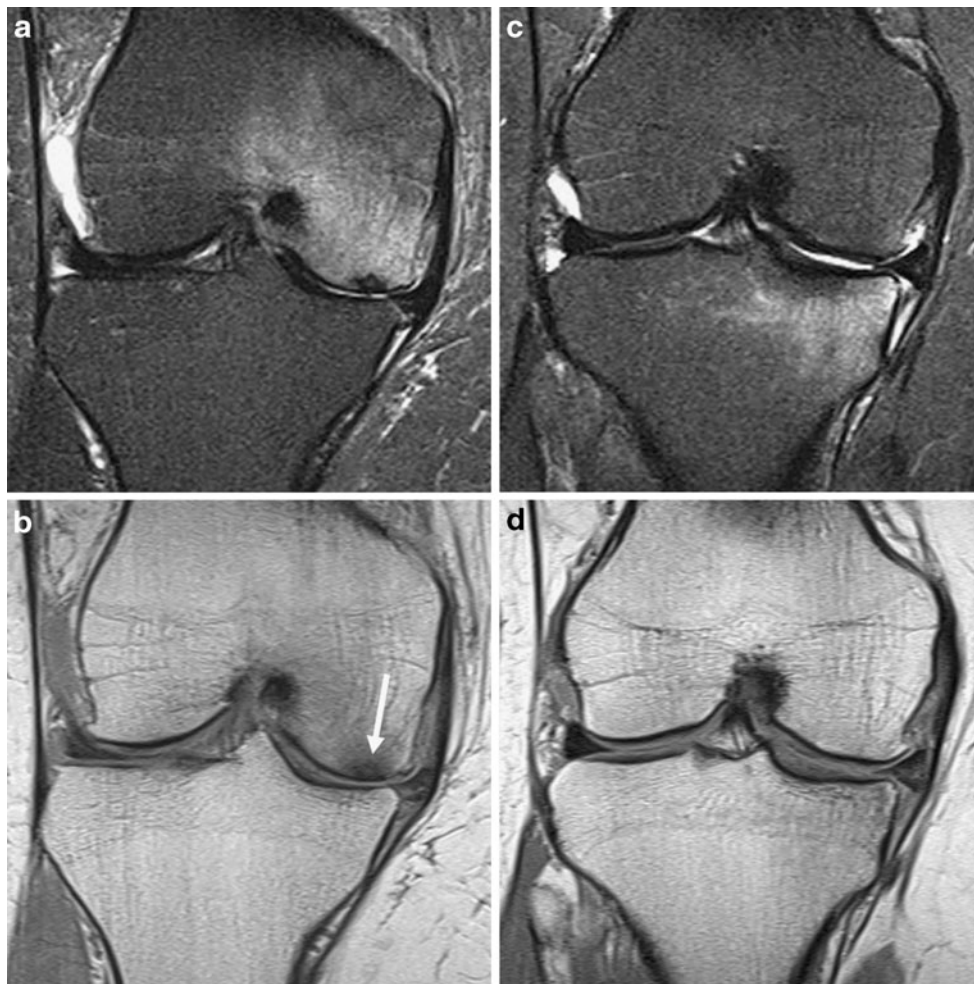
Unpredictability of presence and distribution of bone marrow lesions in osteoarthritis. Right knee MRI in two patients (patient 1 a and b; patient 2 c and d) with STIR and PD images. Two 60-year-old women with right knee pain and instability with recent onset of symptoms with near-normal weight-bearing radiographs 8 weeks previously (preserved joint space with tiny osteophytes only). Both patients had tears of the root attachment of the posterior horn of the medial meniscus (not shown) and some medial extrusion of the body of the meniscus. Cartilage loss is a little worse in the first patient, and an extensive bone marrow lesion in the femoral condyle is associated
